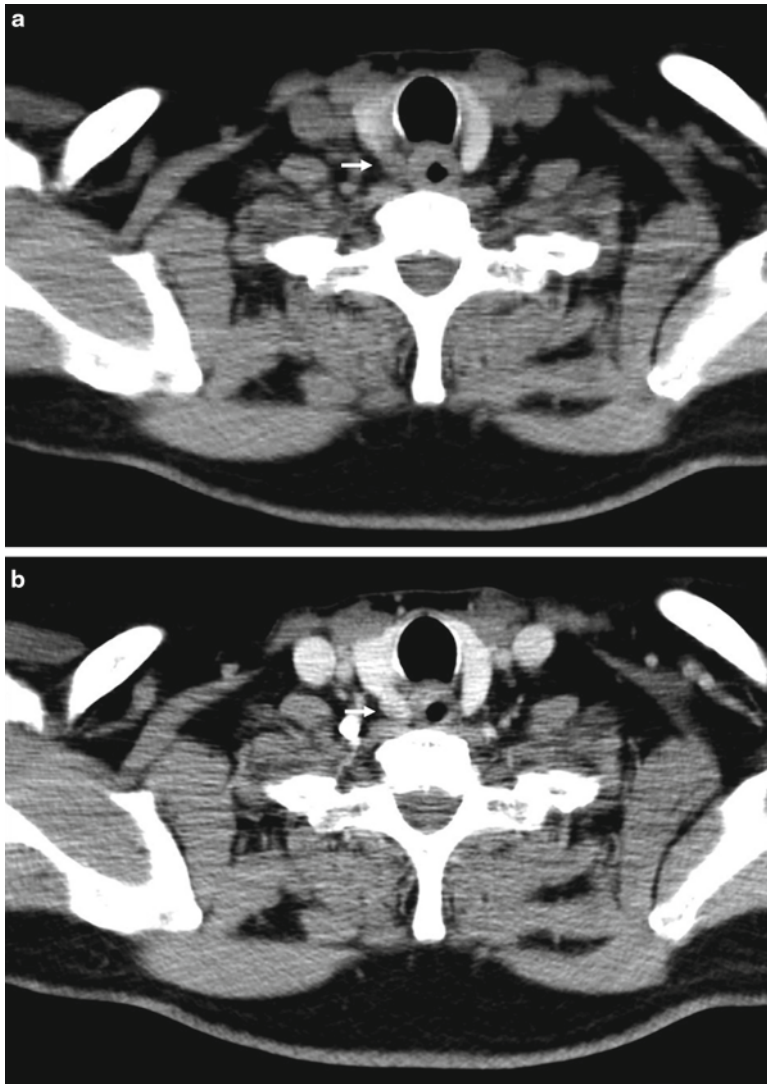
Parathyroid adenoma in the right tracheoesophageal groove. (a) Transverse nonenhanced CT tomogram shows a soft tissue lesion (*arrow*) posterior to the right thyroid lobe. The thyroid is associated with higher CT attenuation characteristics due to its physiologic
